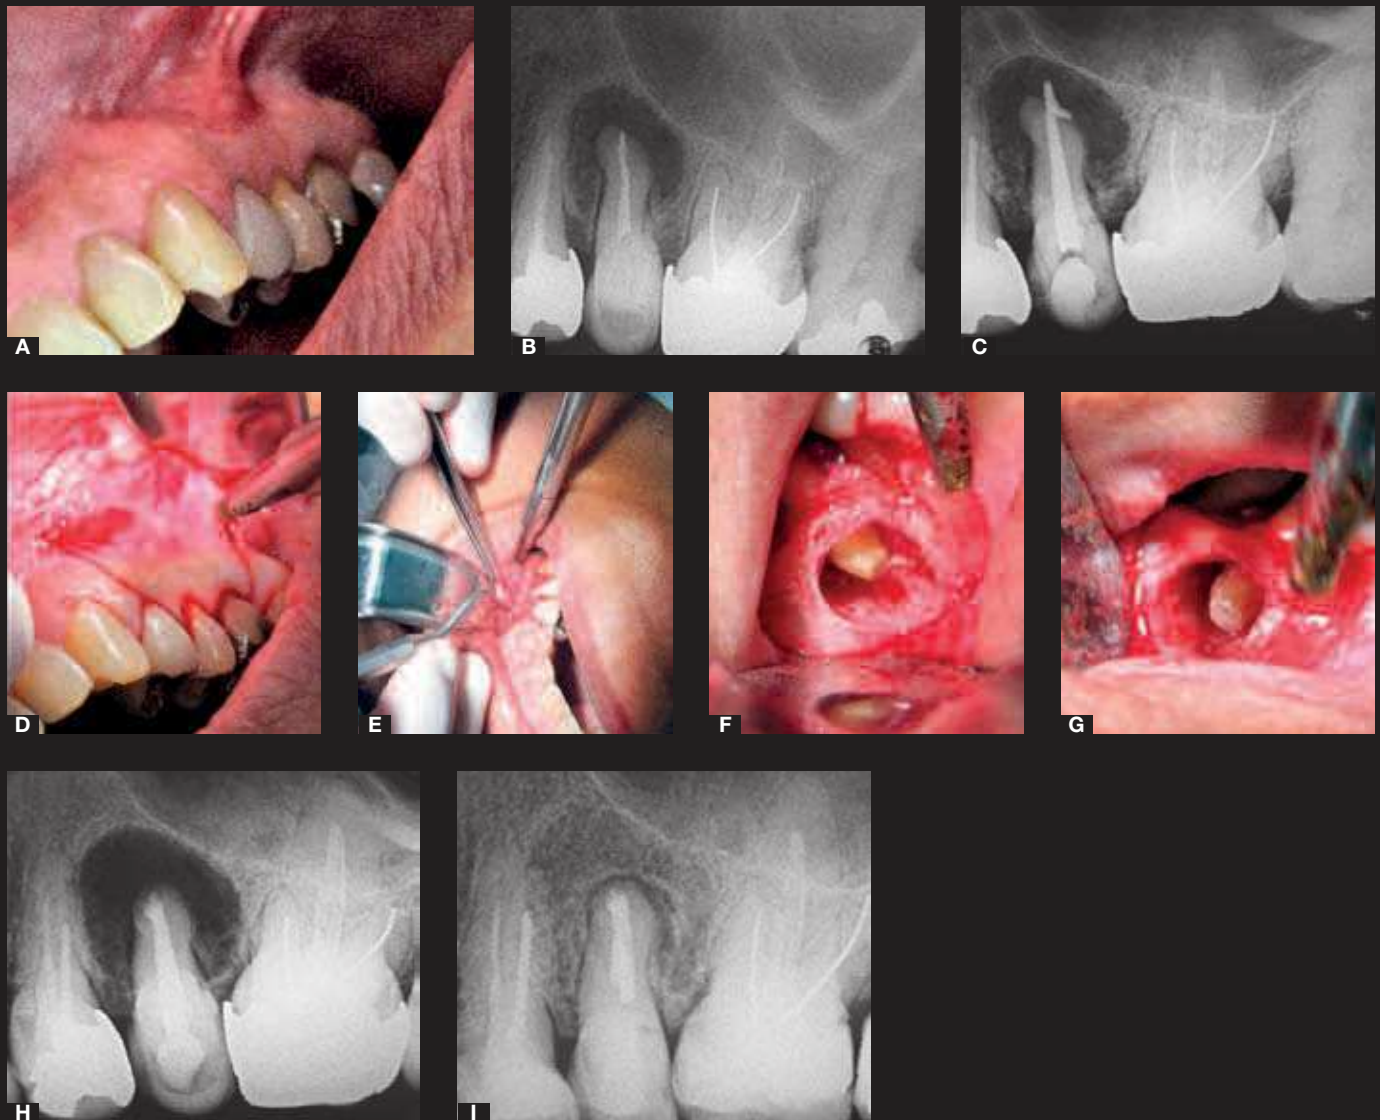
A) Initial clinical presentation including the presence of swelling associated with a fistula on the left maxillary second premolar. B) Periapical X-ray of tooth #25 showing a deviation in the root canal trajectory and unsatisfactory root canal filling prior to root canal retreatment. C) Periapical radiograph after thermoplastic condensation using Tagger's hybrid technique. D) Newman's incision (E) and excision of the periapical lesion. F, G) Apicoectomy without beveling and retrofilling with white MTA. H) Periapical X-ray showing the extension of bone loss after surgery. I) Radiograph showing significant signs of bone healing at one year postoperative.
